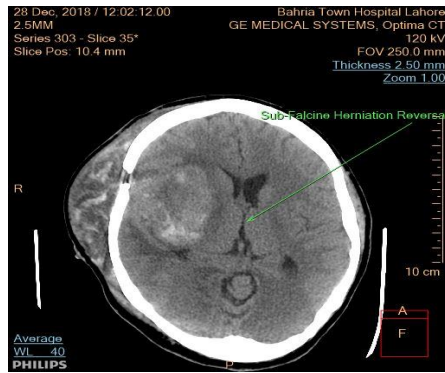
Post-operative imaging following emergency craniectomy in a 25-year-old female with Glioblastoma multiforme. (a) CT scan showing the craniectomy defect. (b) Sub-galeal hematoma formation. (c) Persistent herniation with no significant improvement or reversal signs.
